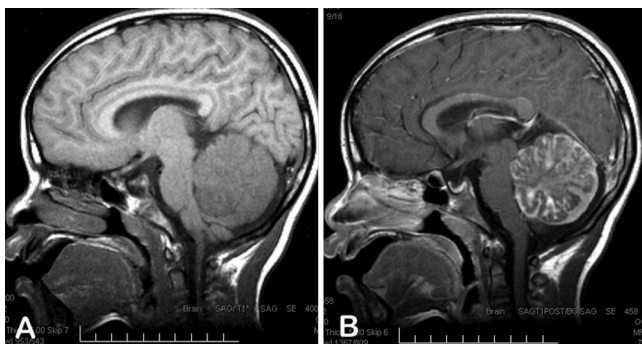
Sagittal T1-weighted MR images of the patient at presentation showing a large nonhomogeneous mass lesion with low isointensity, originating in the cerebellar vermis and measuring 6 cm at the greatest dimension (A), and demonstrating patchy contrast enhancement (B).
